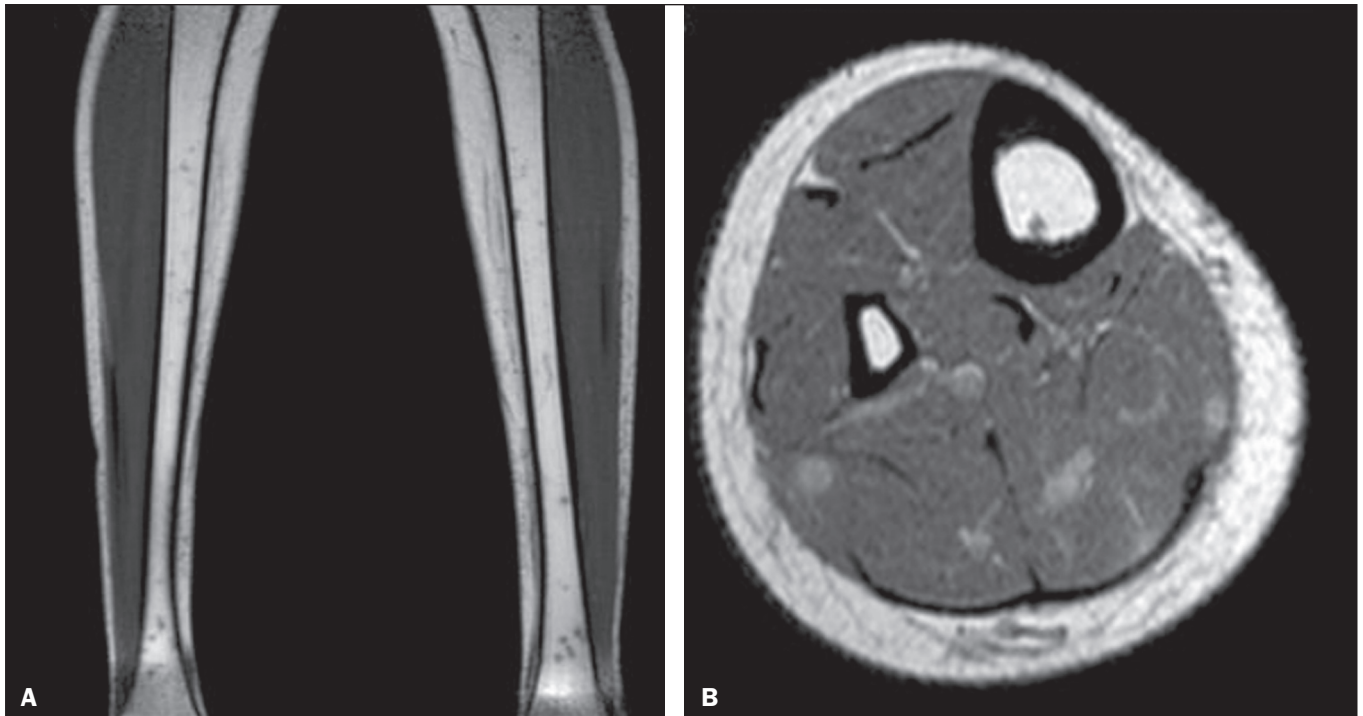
A: Non-contrast-enhanced T1-weighted sequence showing nodules of low signal intensity in the bone. B: Contrast-enhanced T1-weighted sequence showing enhancement of the nodules in the muscle.
